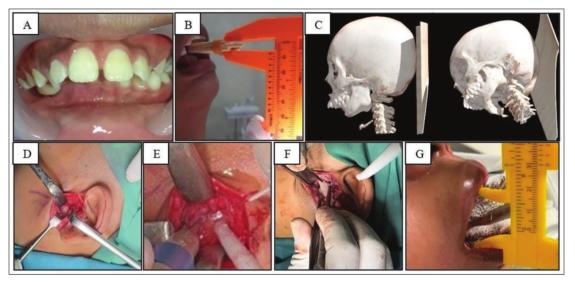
Preoperative mouth opening (A and B), Computed tomography-scan view showed unilateral ankylosis left TMJ (C), bony ankylosis left TMJ (D), gap arthroplasty (E), interpositional arthroplasty with Mersilene mesh (F), 3 months postoperative mouth opening (G)
